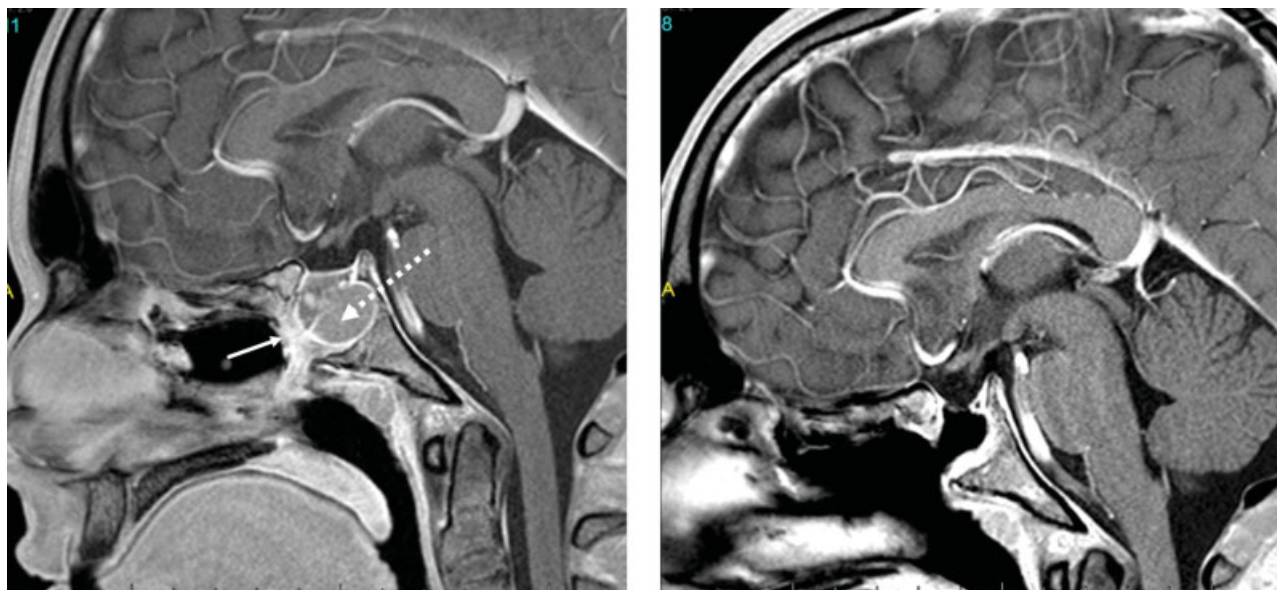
Left image: second recurrence of Rathke's cleft cyst, marked by dashed arrow, with significant scar tissue buildup marked by solid arrow. Right image: 6-month follow-up MRI with no cyst or stent remaining.
